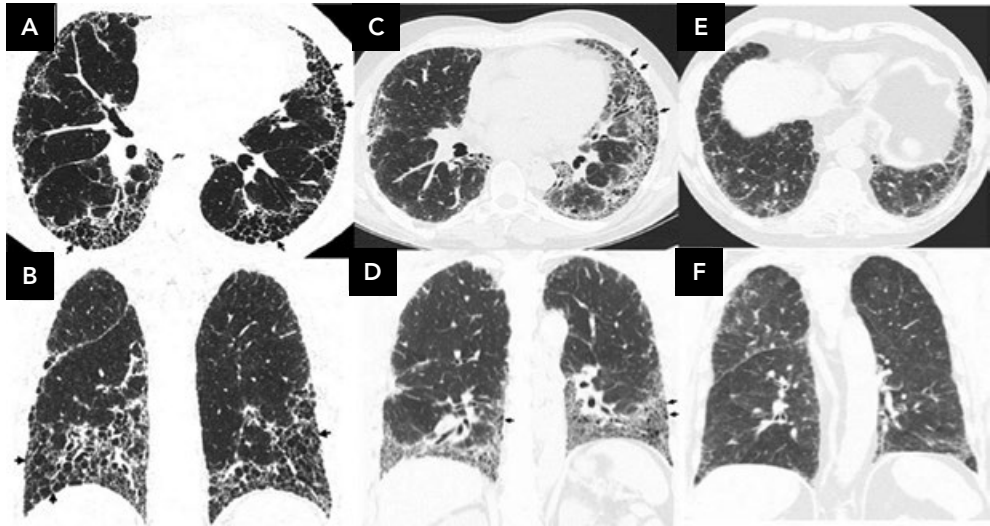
High-resolution computed tomography (HRCT) demonstrating usual interstitial pneumonia (UIP) pattern and possible UIP pattern (5).
